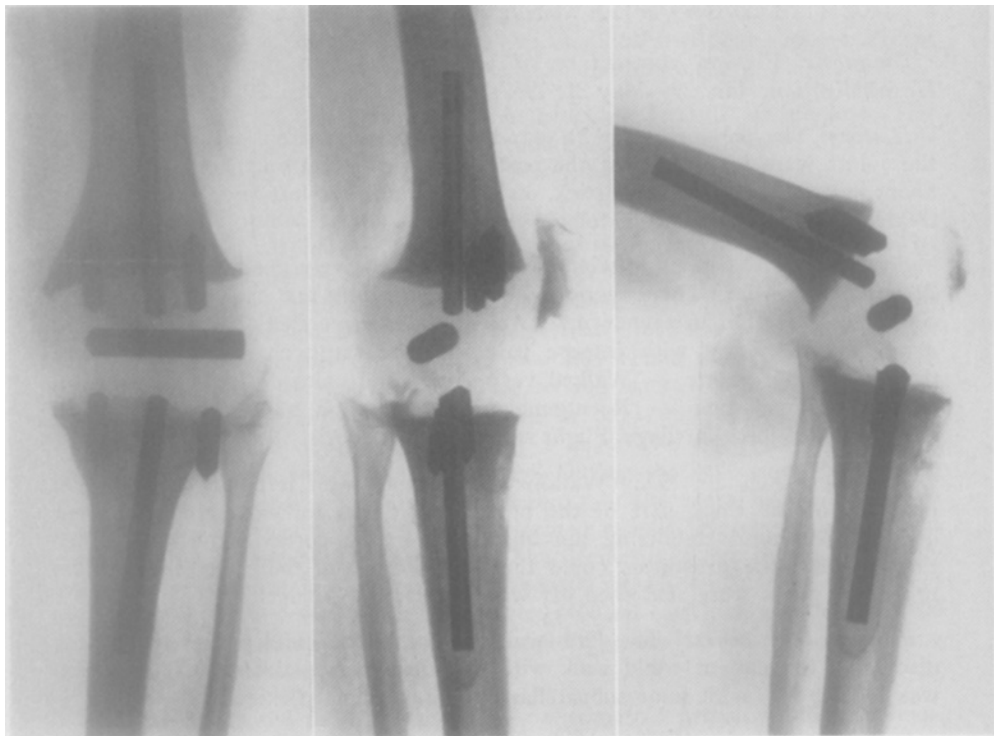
Case 2: roentgenograms 23¼ years after arthroplasty of left knee.
